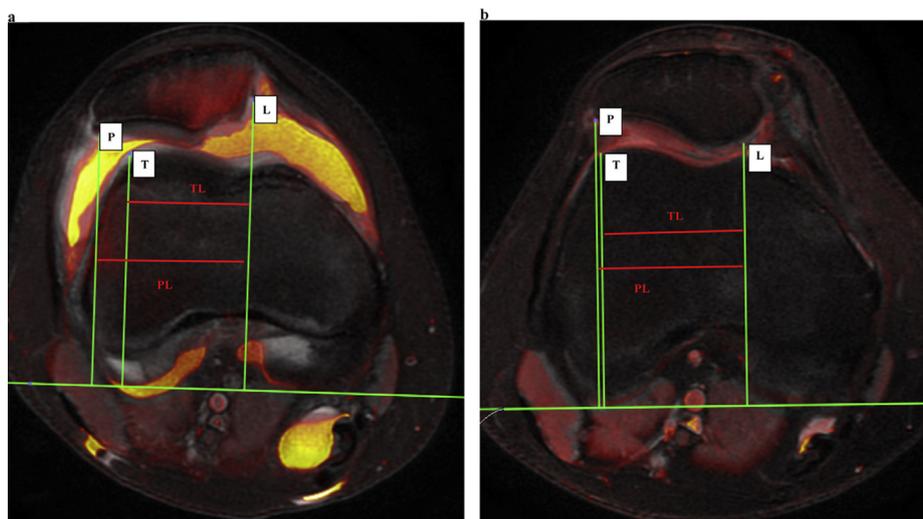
Measurement of the axial patellar engagement index by magnetic resonance imaging. a: before surgery; b: after surgery. Two superimposed slices are used to identify the trochlear and patellar cartilaginous landmarks. The view on which the lateral trochlear facet is largest is selected. The posterior condylar axis (PCA) is drawn (or transferred to this view if the posterior condyles are more prominent on another view). Point T is marked as the most lateral point of the trochlear facet. The line that is perpendicular to the PCA and travels through T is drawn. The axial slice on which the patella is largest is then selected. Point L is marked as the most medial point of the patellar cartilage. The line that is perpendicular to the PCA and travels through L is drawn. The TL segment is drawn; this segment is the projected length of the patellar cartilaginous surface engaged in the trochlea. Point P is marked as the most lateral point of the patella on the slice on which the patella is largest. The PL segment is drawn; this segment is the projected length of the total patellar surface. Finally, the axial patellar engagement index is computed as the ratio of TL over PL.
